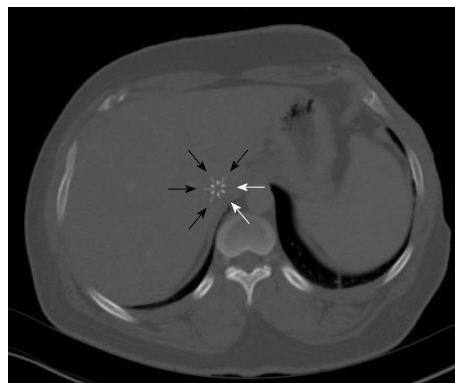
Computed tomography of the abdomen showing missing limbs of the filter. Black arrows showing 4 outer limbs and white arrows showing the position of missing outer limbs.
